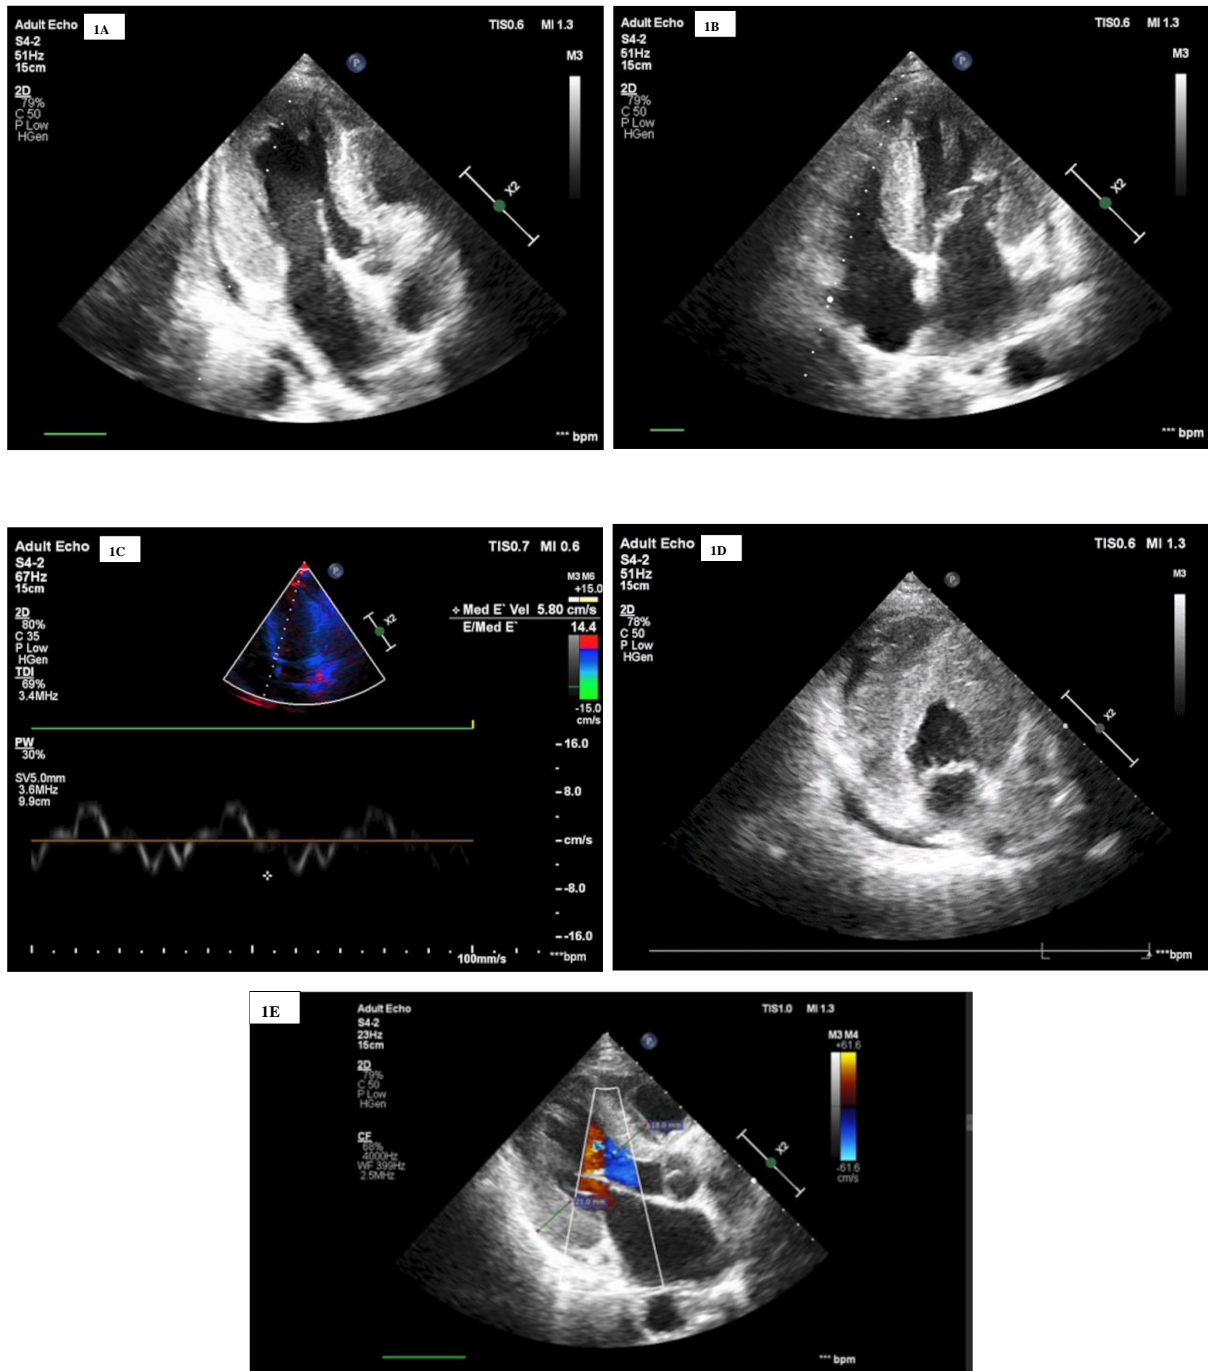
(A) Apical 3-chamber view. Hypertrophy of the left ventricular walls and fluid in the pericardium. (B) Apical 4-chamber view in end-diastole. (C) Tissue Doppler imaging: mitral annular diastolic velocity, (D) parasternal short axis view, and (E) reduced early diastolic mitral annular velocity
